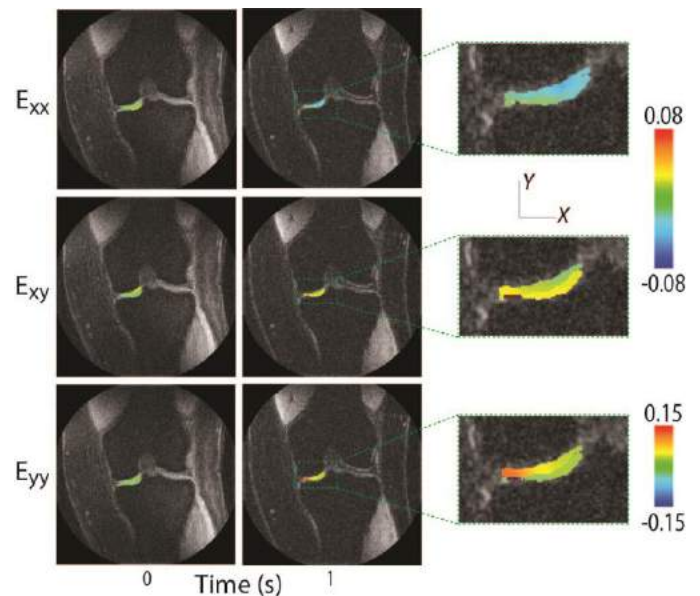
Validation and verification of an MRI-compatible *in vivo* knee varus-valgus loading apparatus using in-lab and MRI sessions. (A) Assembly of the apparatus in a 3 Tesla MRI system. (B) In-lab validation and verification process. Multiple repeated loading cycles were applied for each participant. Data was gathered using a laser displacement sensor. (C) MRI-based displacements were obtained using a spiral DENSE sequence, with full-field maps captured at the beginning and the end of loading cycle. (D) Relaxometry (weighted) images were obtained before and after applying a loading.
